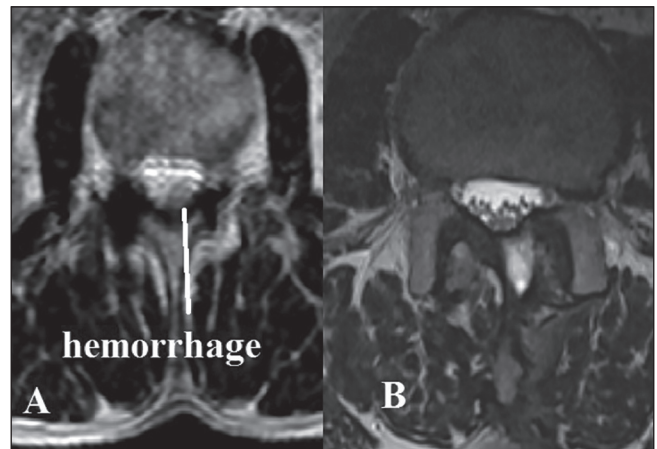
Shows preoperative and postoperative axial MR images of patient
